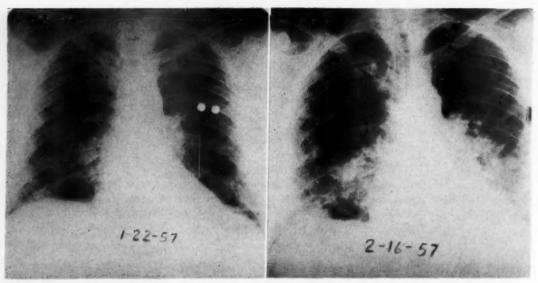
Patient W. H. Roentgenograms of the chest taken on January 22, 1957, and on February 16, 1957.
